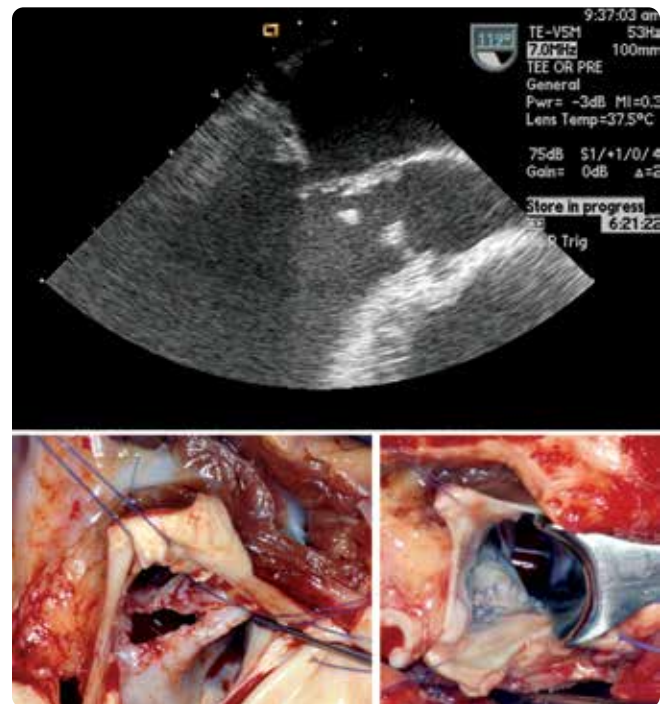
Echocardiogram and operative photos showing a kissing lesion — in which IE vegetations spread from aortic to mitral valve — and its surgical repair.
